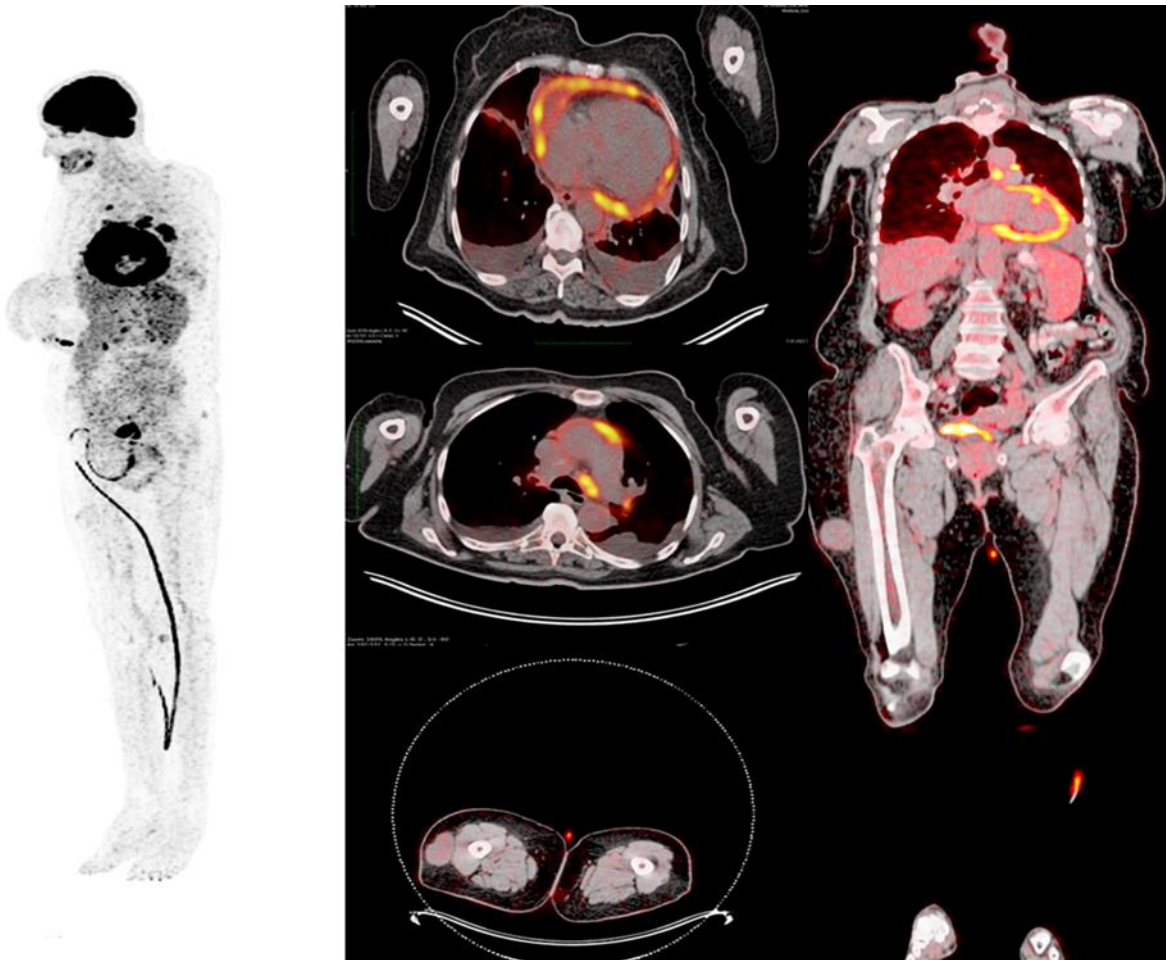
Left anterior oblique MIP image of massive pericardial involvement on the left. On right; PET-CT images of pericardial involvement on the right and lesions on the right lateral thigh in axial and coronal sections.
